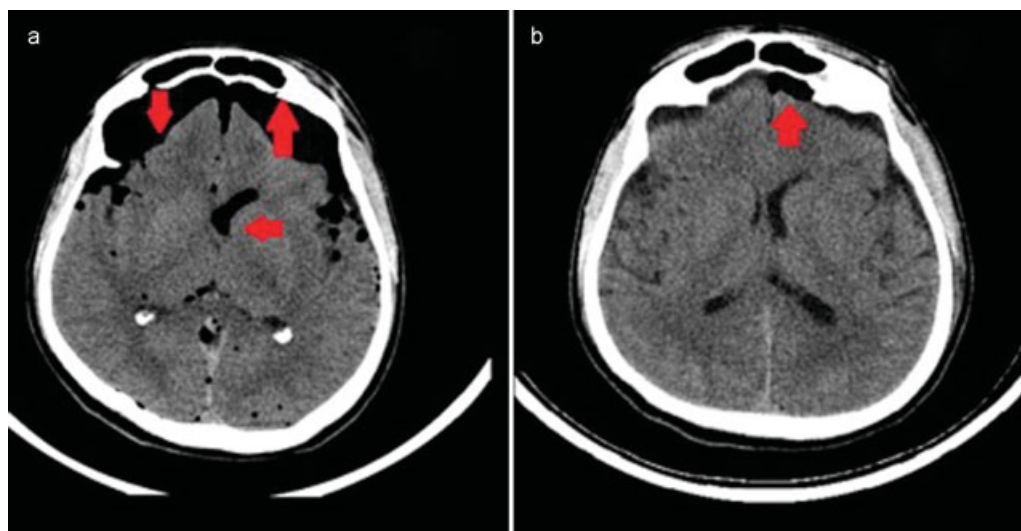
Plain CT scan of the brain, axial cuts, with breach in the inner table of the frontal sinus with gross pneumocephalus and “Mount Fuji” sign depicted with red arrows and left frontal horn pneumoventricle with sylvian air and air bubbles (a). Repeat follow-up CT of the brain showing gross reduction in the pneumocephalus with only residual small pneumo behind the left frontal bone overlying the convexity—depicted with a red arrow (b).
